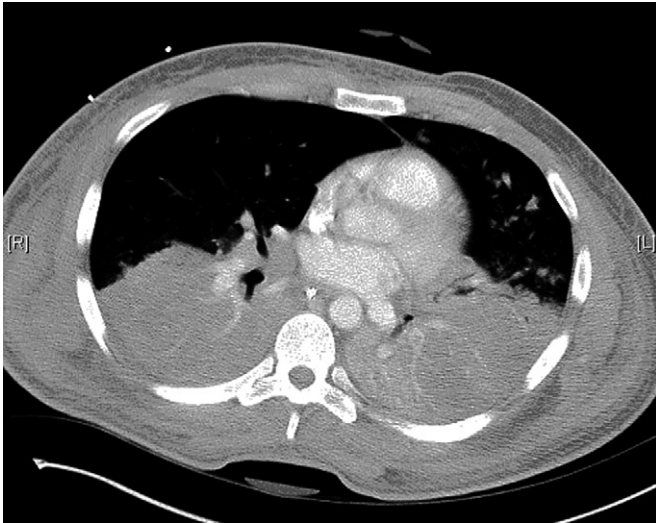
Computed tomography scan of a patient with ARDS due to pulmonary disease (i.e., pneumonia) showing extensive consolidations in the dependent regions and normal aeration in the non-dependent regions.
